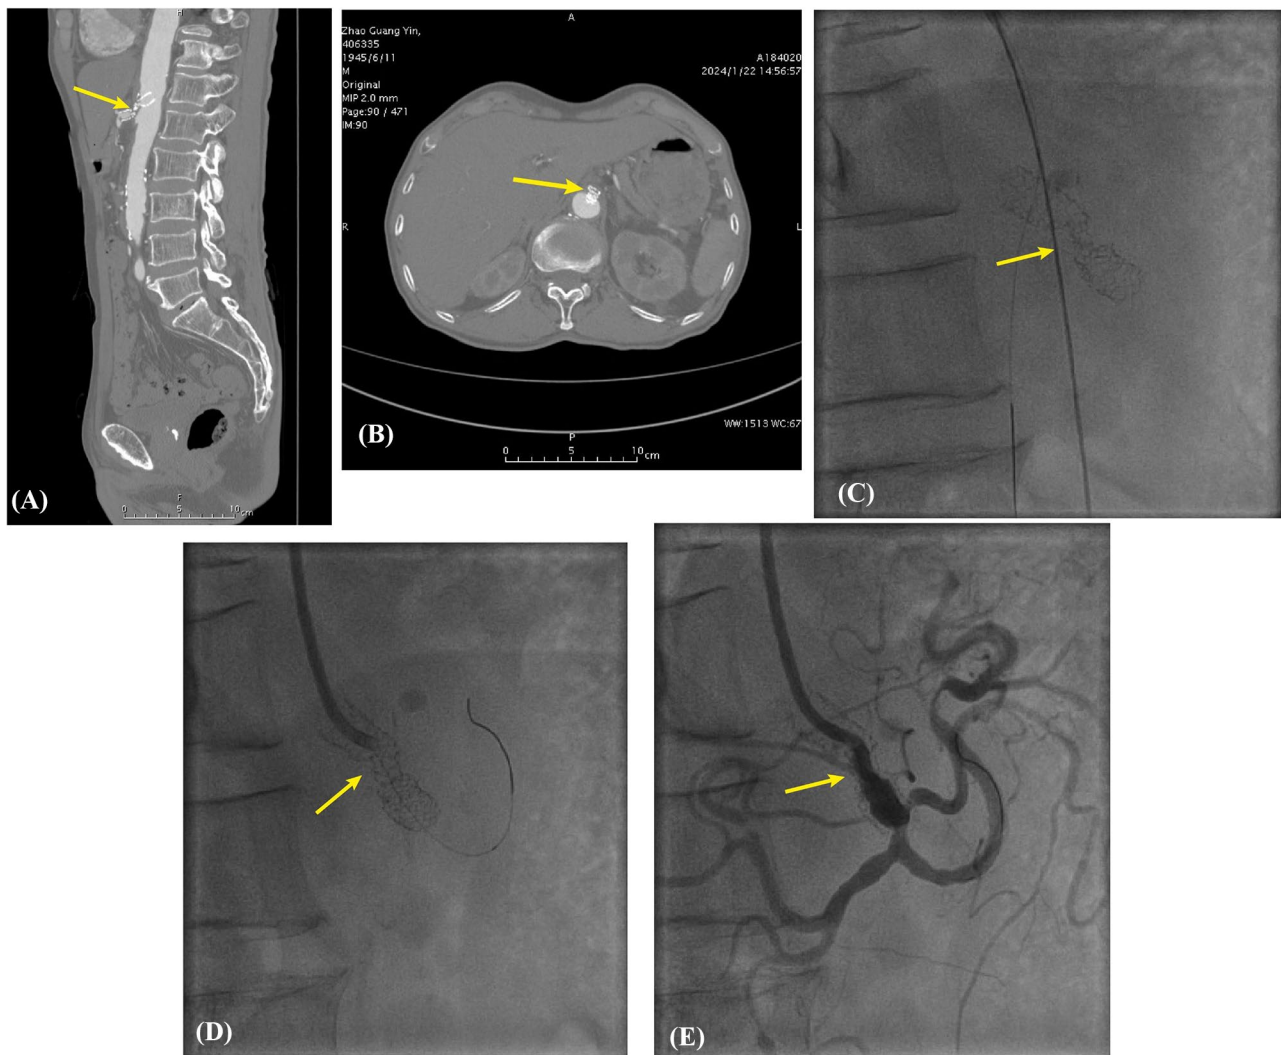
Image of aorta showing the compressed and deformed stent in the ostial celiac artery. (A) CTA image of the aorta showing the stent in the ostial part of the celiac artery was compressed. (B) Axial image at the level of celiac artery origin showing the compression of the stent. (C) celiac angiogram showing the full compression and deformation of the middle part of the stent. (D) balloon angioplasty was performed in the stent by a 6.0*40 mm balloon. (E) celiac angiogram showing < 50% residual stenosis in the middle part of the stent after post-dilation
